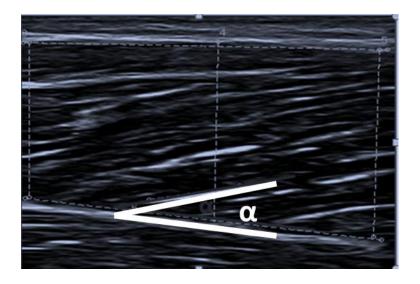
Image of muscle architecture by ultrasonography, with α as pennation angle.
